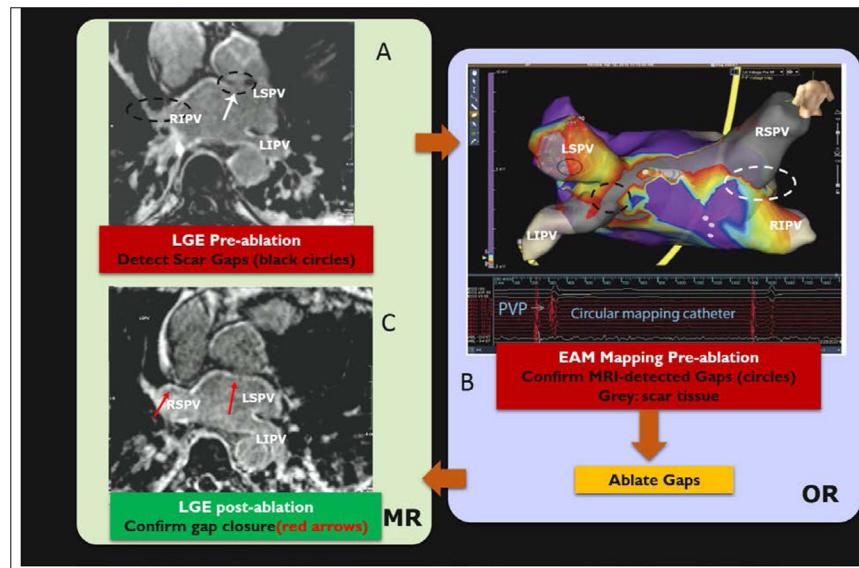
Human procedure for repair of atrial fibrillation recurrence. Procedure involved (A) imaging the patient with LGE and MRA in an MRI prior to the intervention, in order to detect gaps in ablation lesions in the left atrium [lack of hyper-intense signal on the atrial wall], (B) patient transfer to a conventional EP lab where the MRI images were registered to a commercial Electro-anatomic (EAM) map and then the gaps were confirmed by navigating catheters to these locations, measuring wall voltages to establish that the MRI-seen gaps were actually there, and ablating the gaps with RF, and (C) transfer of the patient back to the MRI suite for a post-operative LGE, which confirmed that the gaps were indeed closed. AF has not recurred in any of the 7 patients studied in this protocol. (After Michaud G. F. et al, Proceedings of Heart Rhythm society, 2012⁹²).
